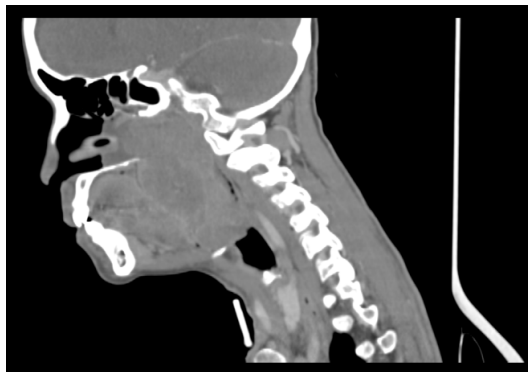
Sagittal plane. Computed tomography of the head. A large mass obliterating nasopharynx, oropharynx, and part of hypopharynx.
